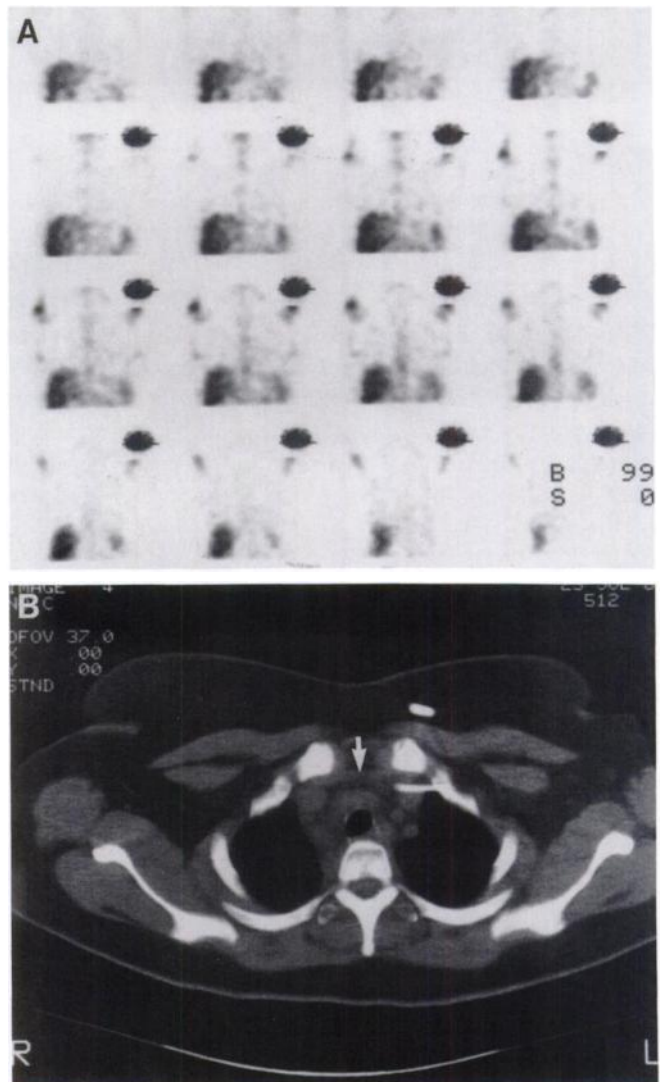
(A) A 20-yr-old female with Hodgkin's disease, Stage IIB, was treated with chemotherapy which was completed 2 mo prior to imaging. The patient was referred for restaging upon completion of therapy. Coronal images on the SPECT study demonstrate normal distribution of radiotracer throughout the visualized thoracic structures with no evidence of recurrent or residual disease. (B) CT scan of the same patient demonstrates residual disease in the anterior mediastinum (arrow). Biopsy of the anterior mediastinal lymph nodes was negative for Hodgkin's disease. The biopsy material was fibrotic in part.
